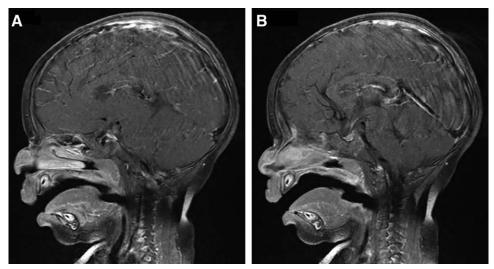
Sagittal T1-weighted MRI; A, Demonstrating an 11-mm diameter mildly enhancing right paramidline mass at the base of the nose. The mass appears to be extranasal in location, superficial to the nasal bones, and there is restricted diffusion of the lesion; B, Demonstrating an enhancing fibrous stalk that extends from the mass superiorly and posteriorly through the foramen cecum into the intracranial compartment.
